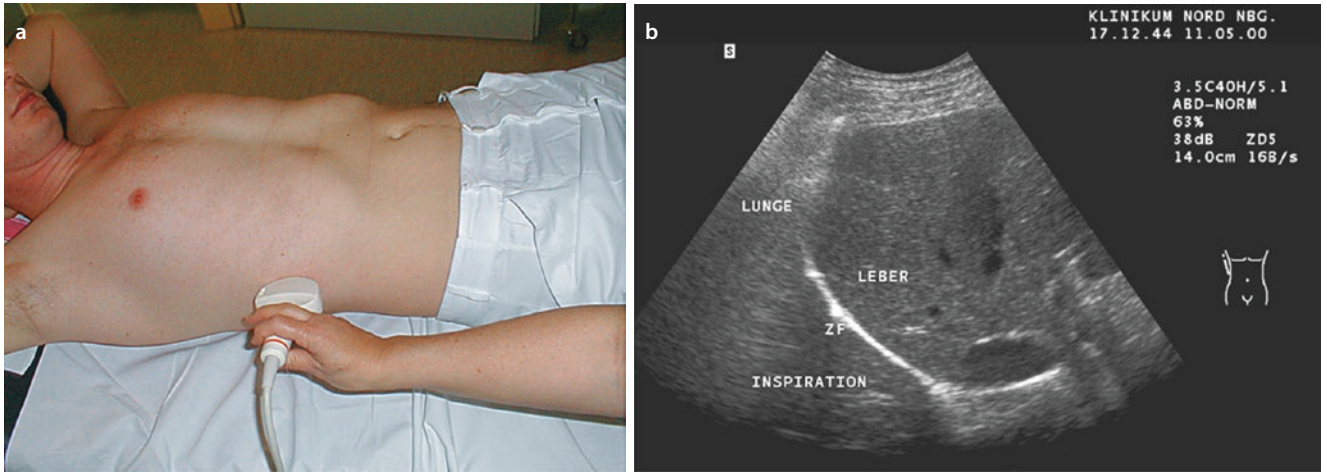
Investigation from the lateral aspect. a Convex probe placed longitudinally in the mid-axillary line on the right side. b Corresponding ultrasound image (ZF diaphragm). A lung with normal
